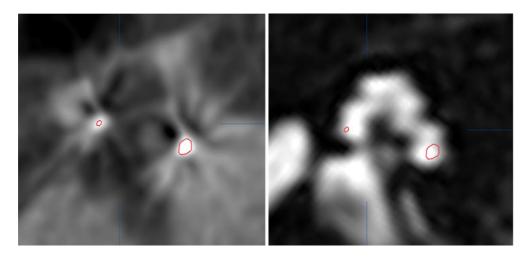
Electrode reconstructions (red) on postoperative CBCT (left) and preoperative MRI image fusion (right). The cochlear topography can be better defined on the MRI image fusion reconstruction and hence the electrode location in the scalae can be assessed more accurately.
